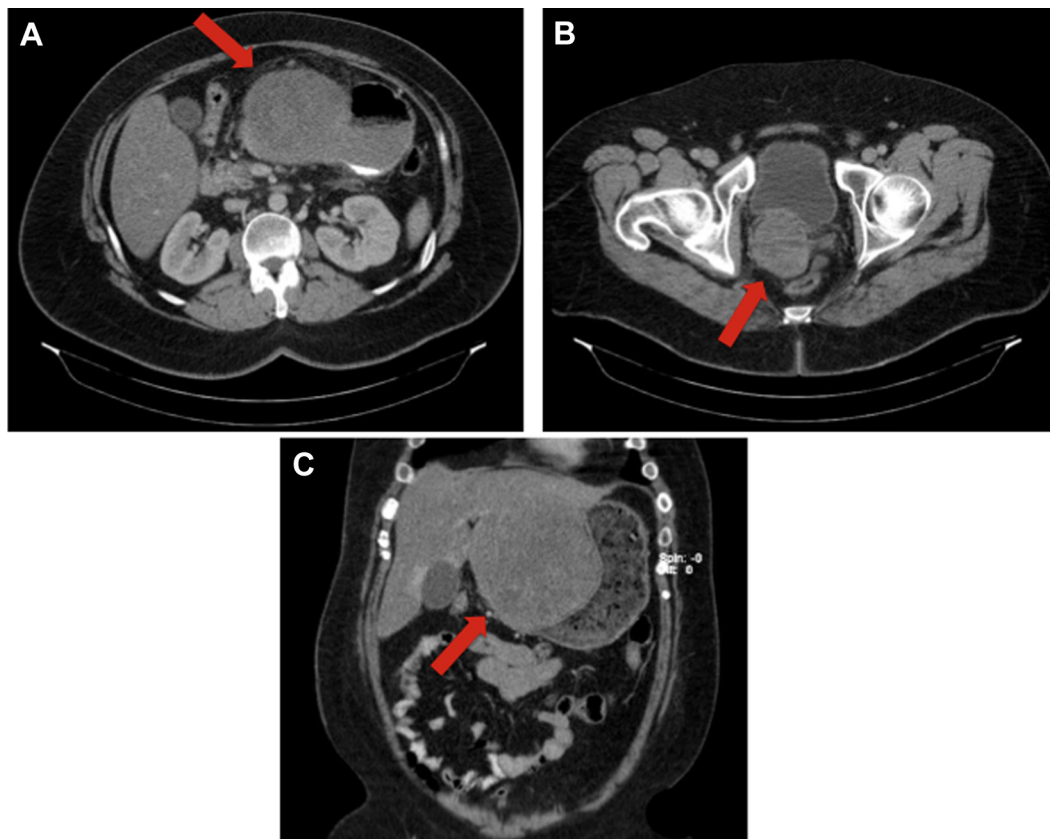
CT abdomen/pelvis on initial presentation, axial (A,B) and coronal (C). These images demonstrate the duodenal mass (A, C), and the pelvic mass (B), which were identified at presentation, the red arrows point to the “duodenal mass,” and “pelvic mass”.
